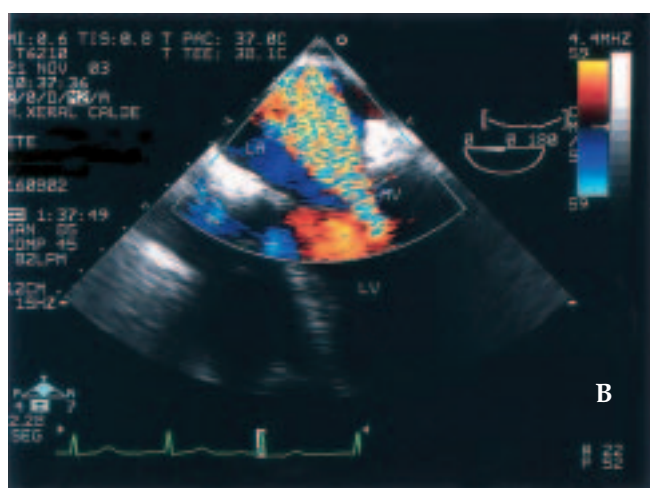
A) Diastole frame horizontal transesophageal echocardiographic view of the mitral valve, showing two leaflet vegetations (arrows). B) Horizontal transesophageal echocardiographic view showing a mitral regurgitation color jet almost reaching the posterior wall of the left atrium. The mitral regurgitant volume (64 ml) was calculated using the PISA method. LA: Left atrium; LV: Left ventricle; MV: Mitral valve.
